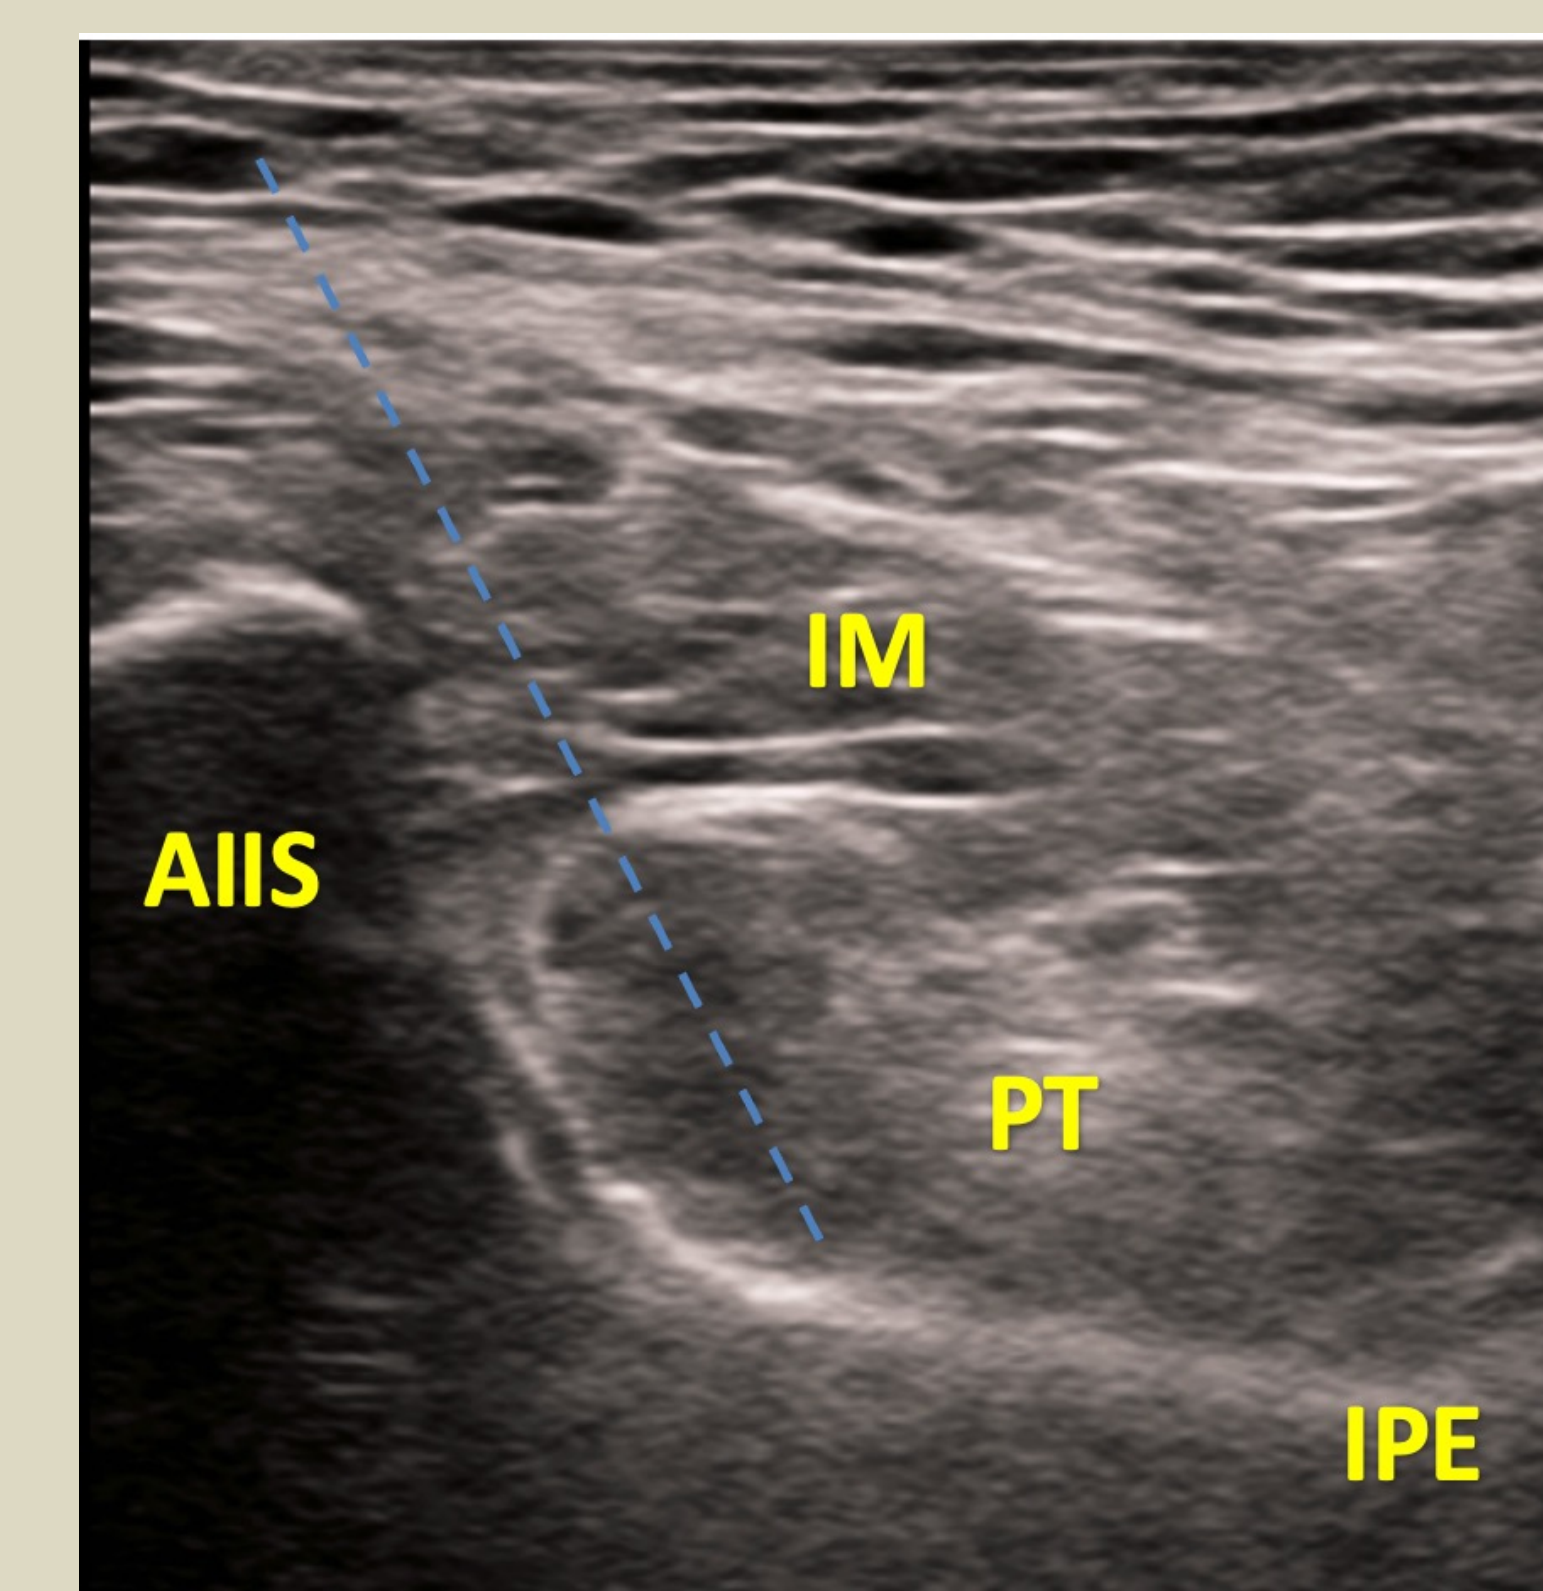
Ultrasound PENG block IM: iliacus muscle; AIIS: anterior inferior iliac spine; PT: psoas tendon; IPE: iliopubic eminence.
